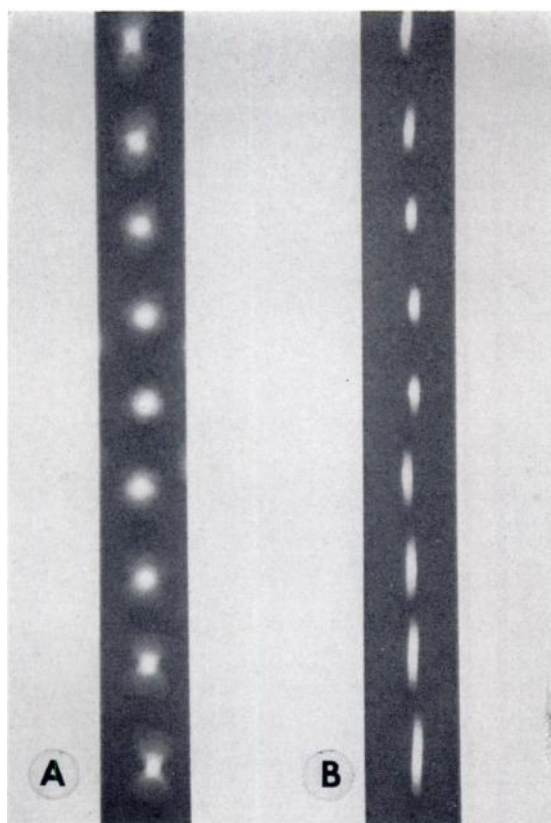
(A and B) Stieve test pattern showing incomplete marginal occurrences of x-ray beam with hypocycloid movement (A) and incomplete tangential occurrences with linear movement (B).
